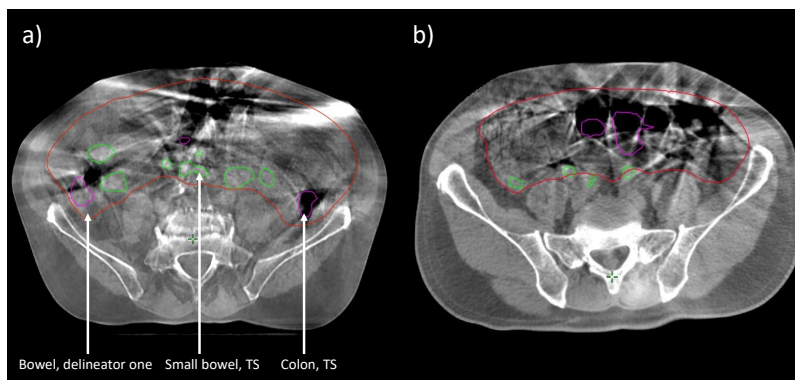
A CBCT slice of patient a) ER13 and b) ER3 occupied by artifacts. The bowel (red) is segmented by delineator one and the small bowel (green) and colon (magenta) by TotalSegmentator (TS).
